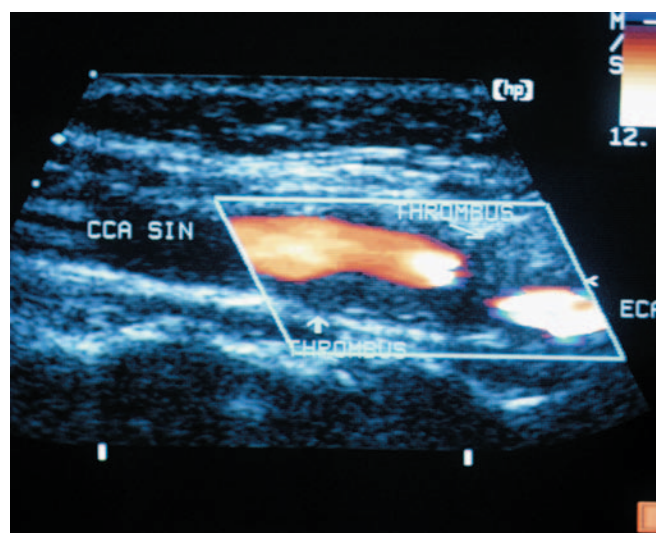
Duplex sonography of the branching of common carotid artery. Thrombus filling up the origin of the internal carotid artery is indicated with an arrow in the right part. Thrombus on the posterior wall of the bulb of the common carotid artery is indicated by the vertical arrow. CCA SIN – left common carotid artery, ECA – external carotid artery
